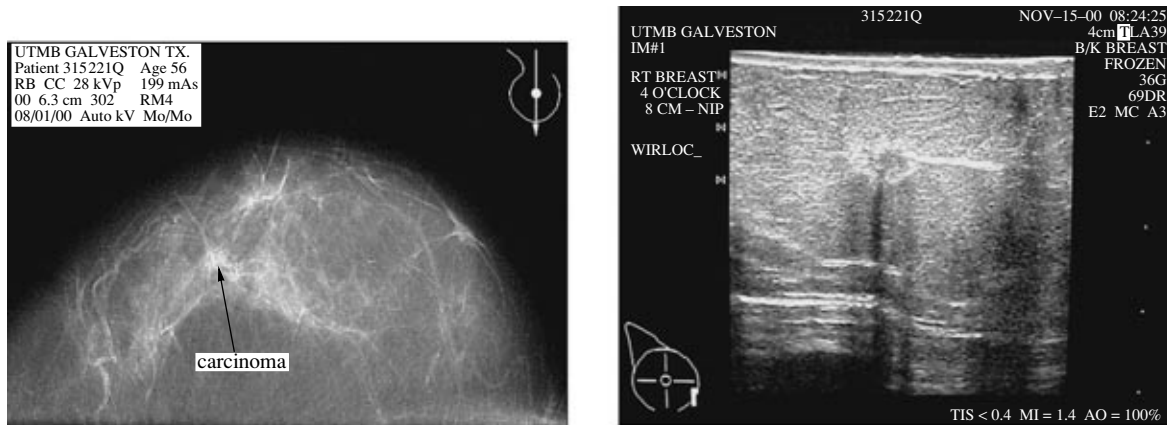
X-ray mammography image of a cancerous breast (left). There were two suspicious areas on the mammogram; only one of them was a ductal carcinoma. Ultrasound image of the same breast showing a malignant tumor. UTMB Patient 315221.
